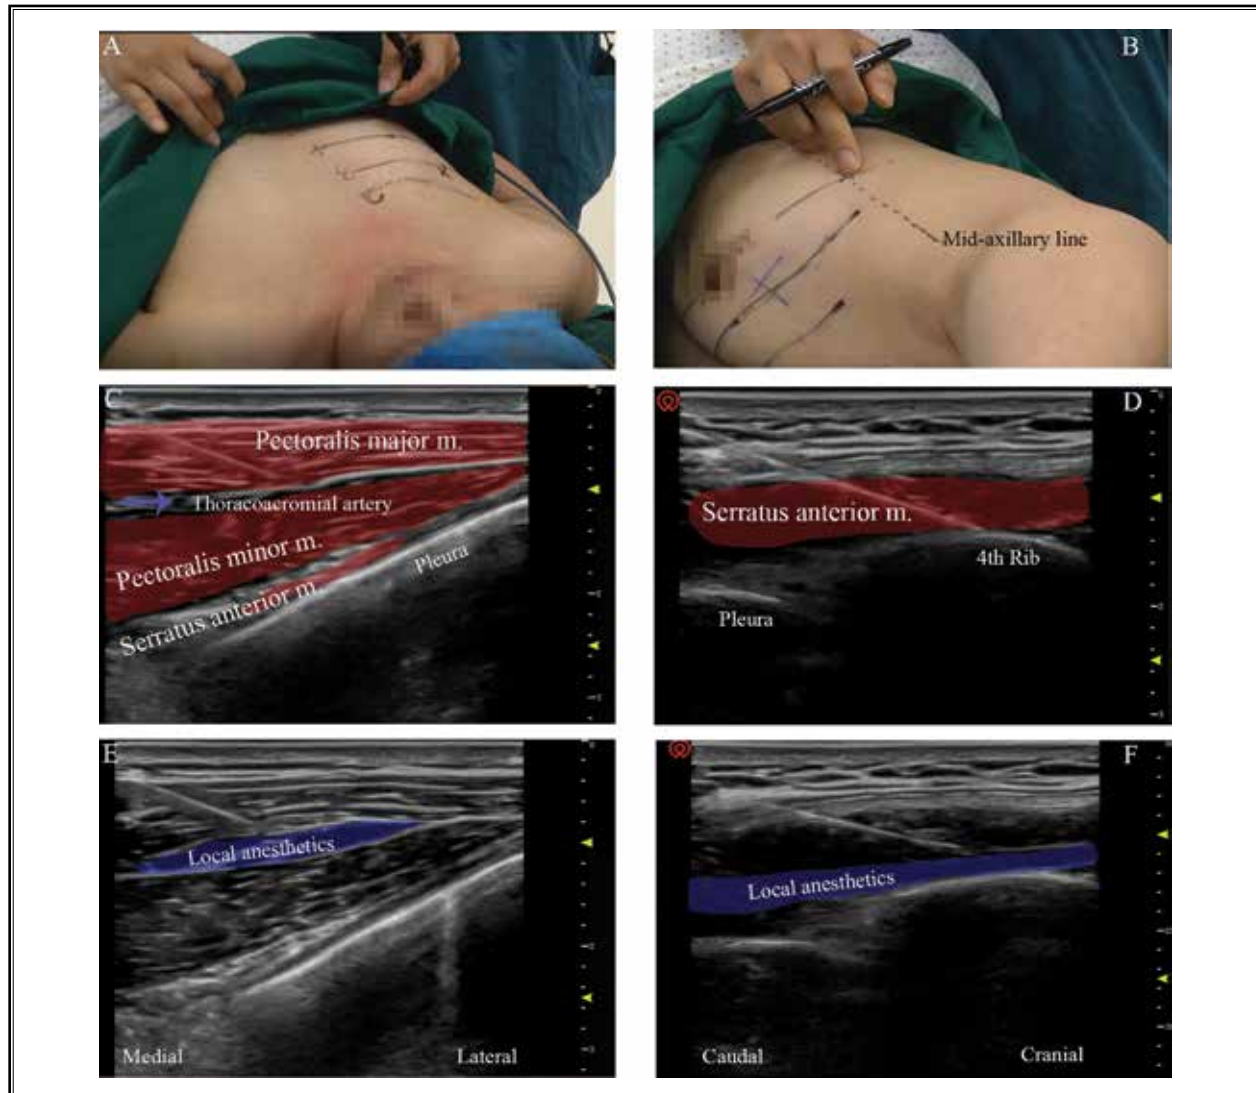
Sonographic anatomy of ultrasound-guided PECS I (A,C,E) and SPB (B,D,F). (A-B) Position of the ultrasound transducer and needle. (C-D) Ultrasound images of the muscles forming the anterior and lateral chest wall, and puncture route of the linear ultrasound transducer. (E-F) The spread of local anesthetics in the interval fascia between the pectoralis major and minor muscles for PECS I, and under serratus anterior muscles for SPB.
